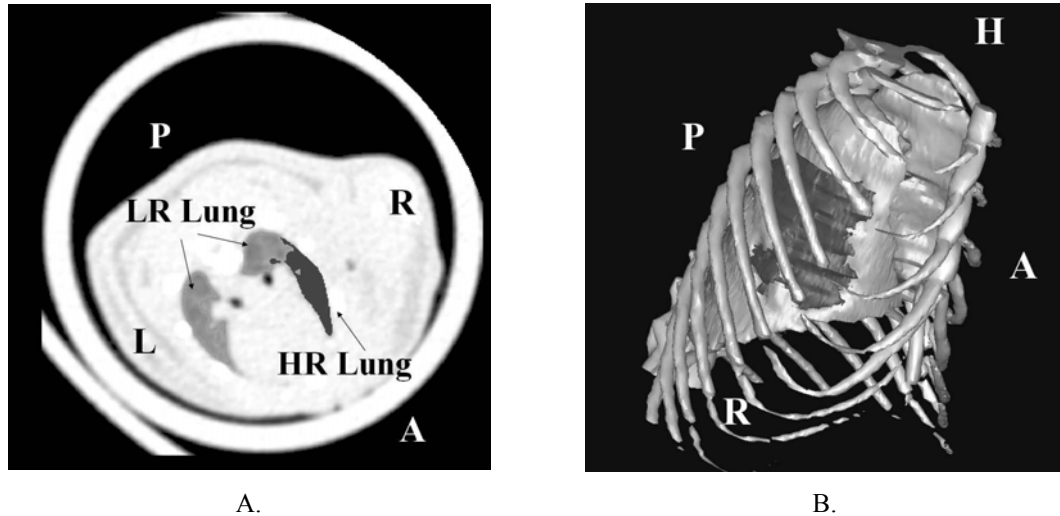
CT image results, anatomical directions indicated in block letters, P, Posterior, A, Anterior, R, Right, L, Left, H, head. A. Transverse slice showing high and low radiopacity lung volumes. B. 3D reconstruction of high (dark) and low (light) radiopacity lung, rib cage shown but not included in analysis.
